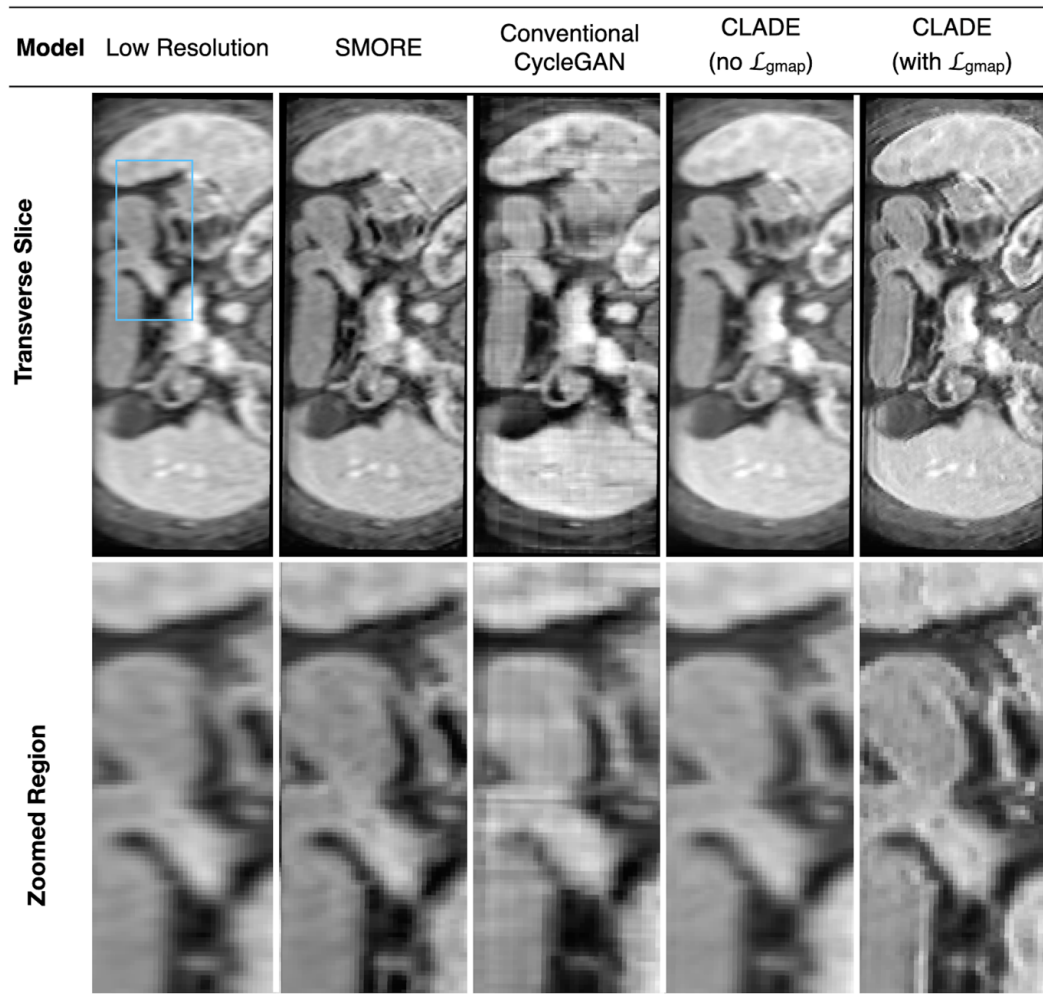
An example of transverse image quality from SRR applied to a low-resolution MRI data from one subject in the test dataset. Note that the SRR models are applied in the low-resolution sagittal plane for the MRI data, where this figure shows the resulting volume reformatted in the (low-resolution) transverse plane. Magnified regions within the blue box are displayed beneath each image.
